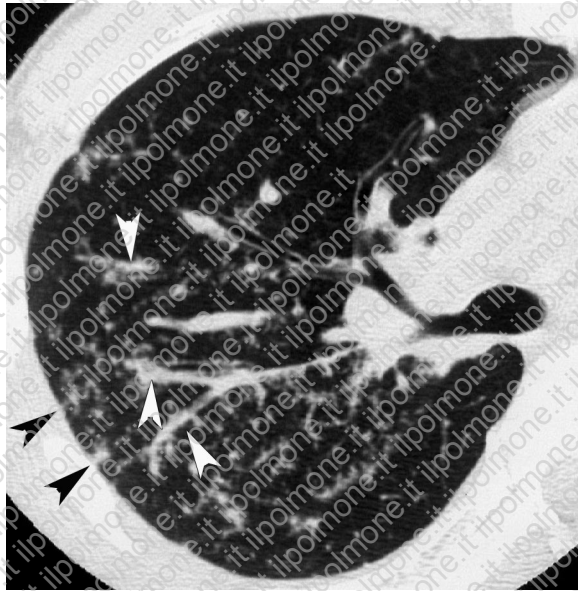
Pulmonary sarcoidosis in a 37-year-old man. High-resolution chest CT scan demonstrates small nodules with a perivascular distribution and irregular thickening of bronchovascular bundles (white arrowheads) and interlobular septa (black arrowheads). These findings reflect the pathologic distribution of sarcoid granulomas along the lymphatic vessels within interstitial tissue.
